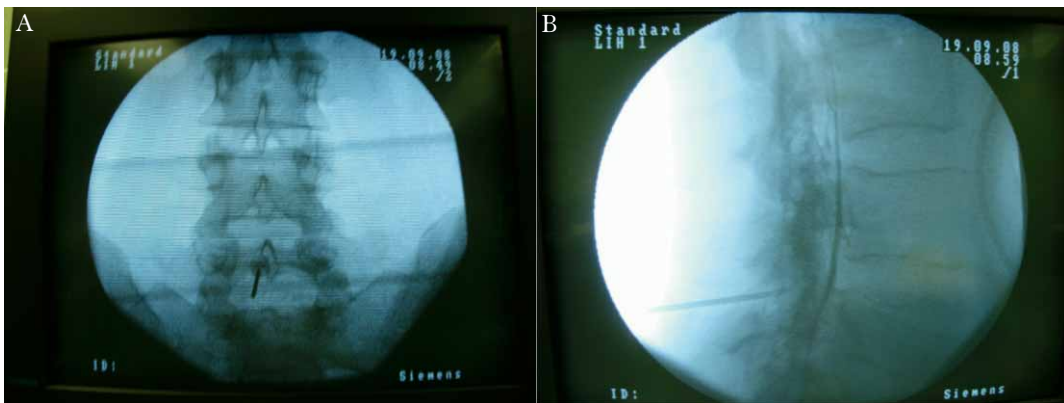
A. Anterior-Posterior radiograph of the lumbar spine during interlaminar lumbar epidural injection. B. Lateral radiograph of the lumbar spine during interlaminar lumbar epidural injection.
